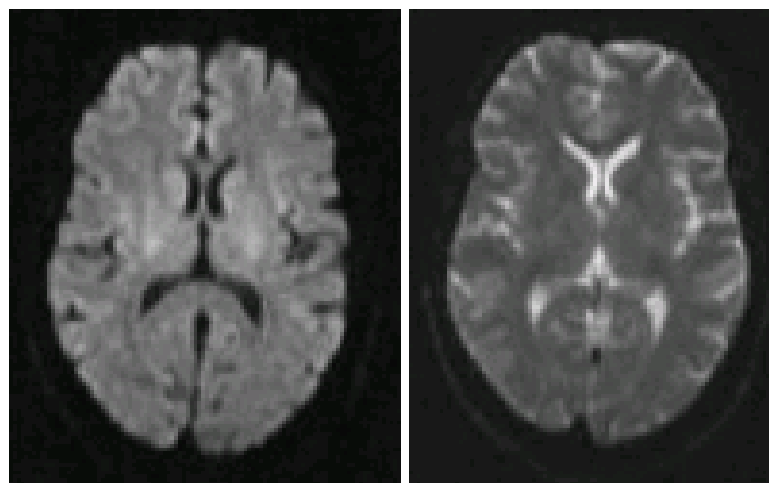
Inverted intensity scale of the ADC map (right) relative to the DWI (left) used to calculate it (normal brain of a 35 year old man).
